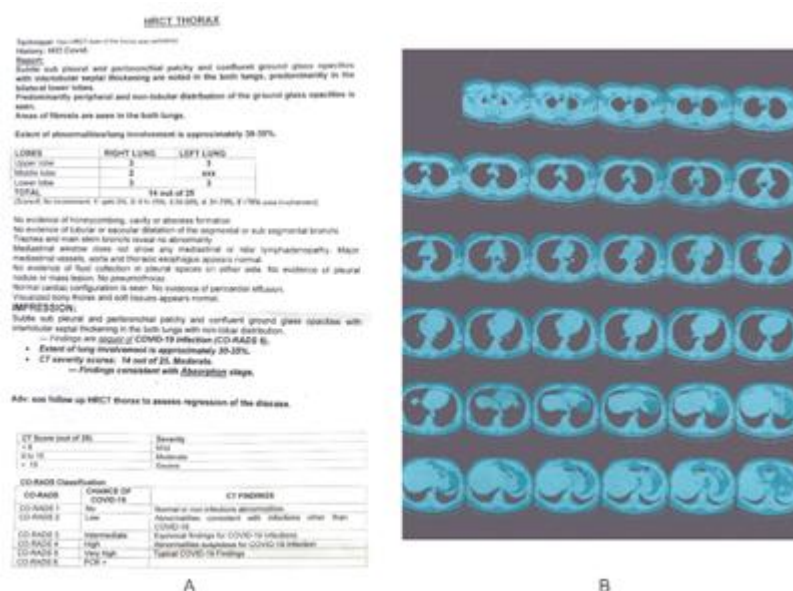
Follow up HRCT Thorax (A) Report and (B) Scan
